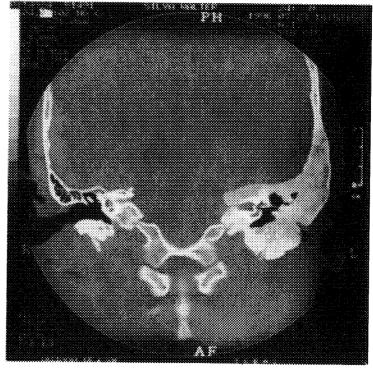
Coronal CT scan: shows the stenosis of the external auditory canal of the left side.
